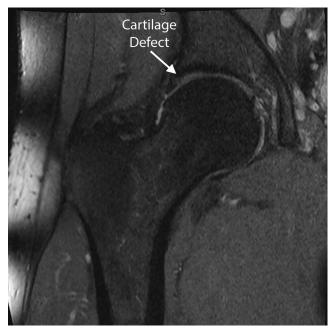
Coronal magnetic resonance image of a right hip showing a superolateral cartilage defect in the acetabulum.
